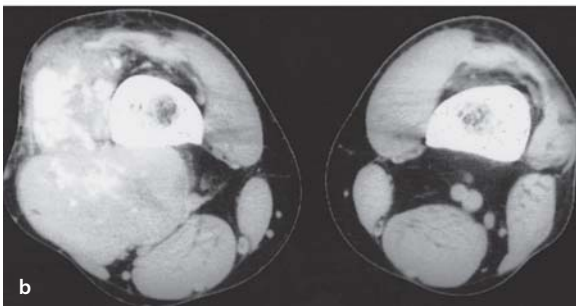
a, b. Synovial sarcoma arising in the vastus lateralis in a 66-year-old man. a Plain radiograph. b CT. Both imaging techniques demonstrate amorphous calcification
